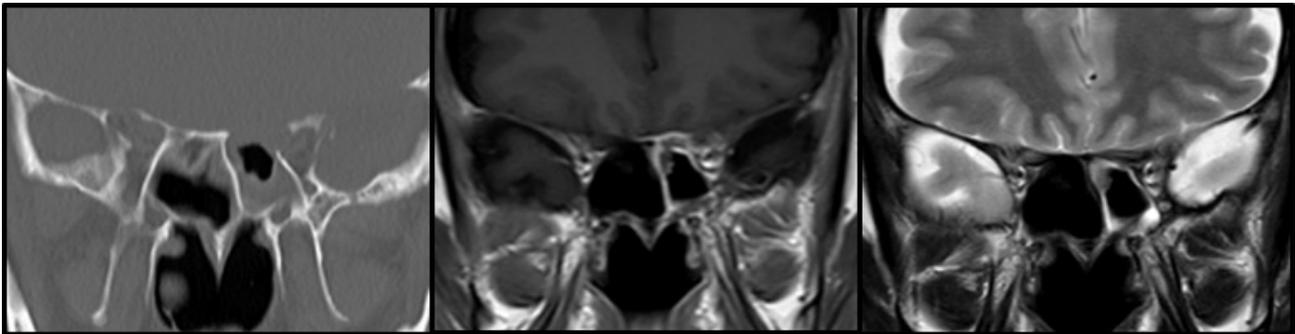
CT scan show an opacification of left sphenoidal sinus and an erosion of all bony boundaries. MRI in T1 show a peripheral isointense and central hyperintense opacification while in T2 sequences peripheral hyperintense and central isointense with a signal void sign in the central part.
